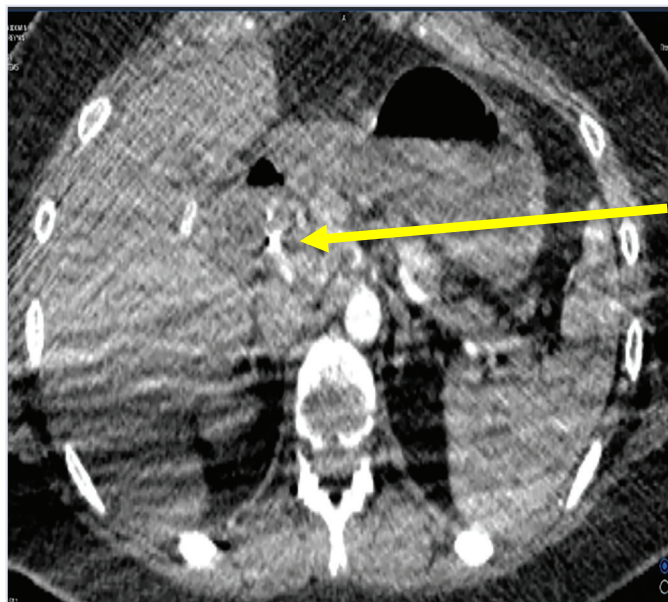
Postoperative CT angiography showing patent saphenous vein graft on postoperative day 5. White arrow indicates the course of the graft and confirms arterial continuity without thrombosis (yellow arrow).
